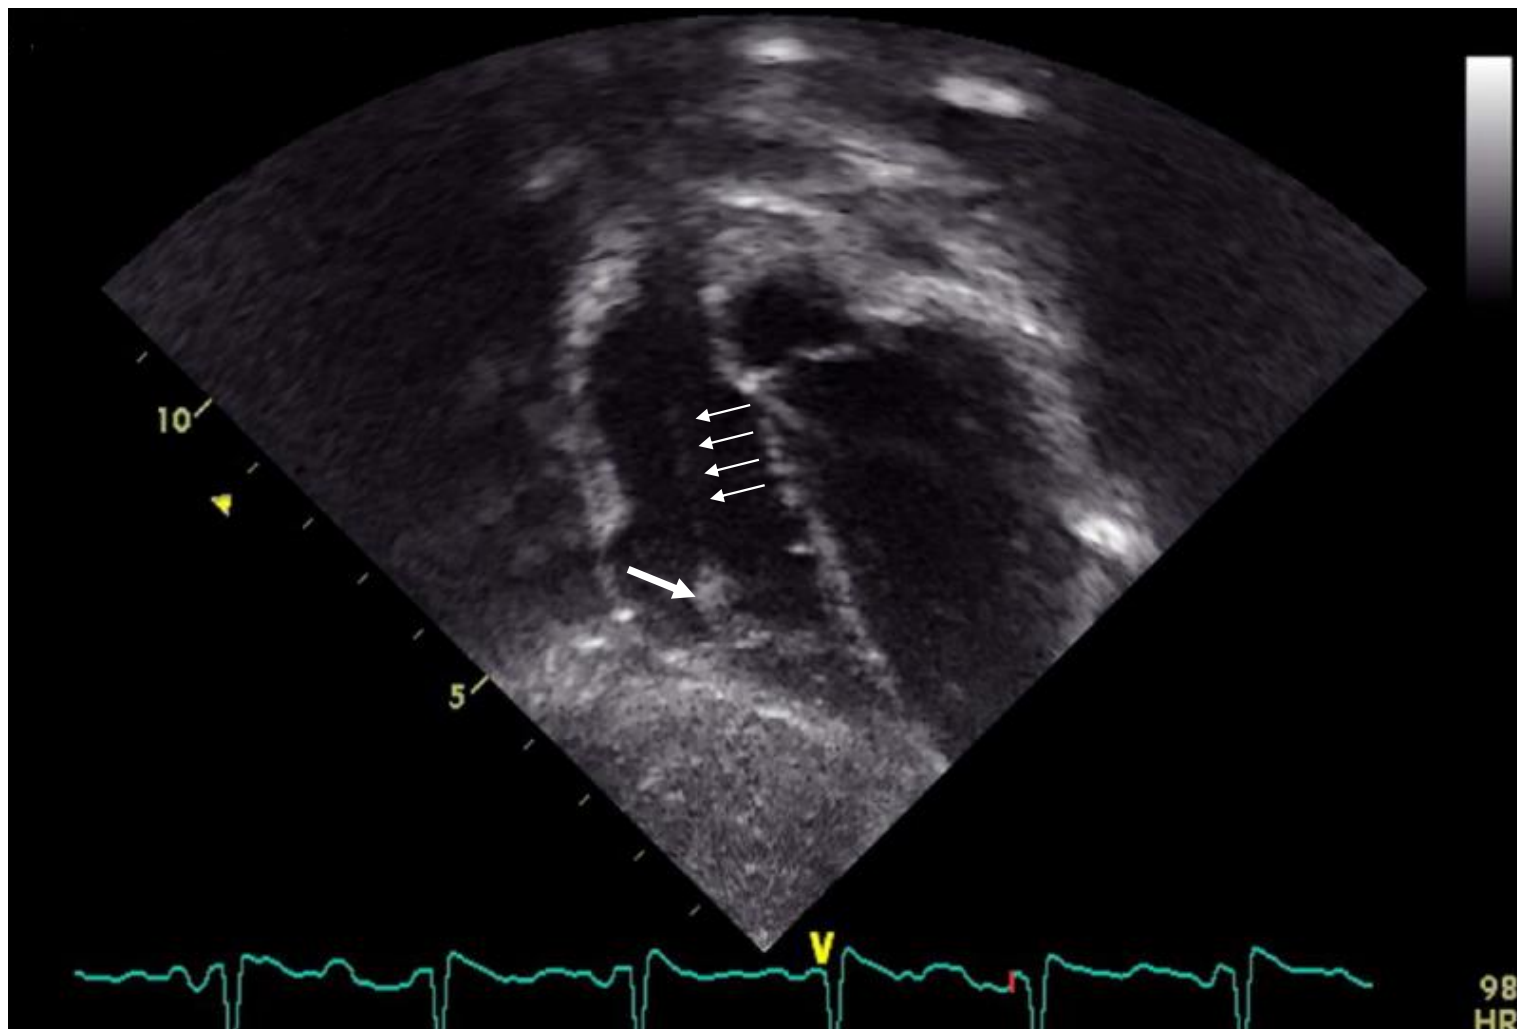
Intra-procedural echocardiography, modified four chamber subcostal view showing the course of the shunt fragment through the right ventricle (small arrows) and dense tissue at the end of the fragment (large arrow).
